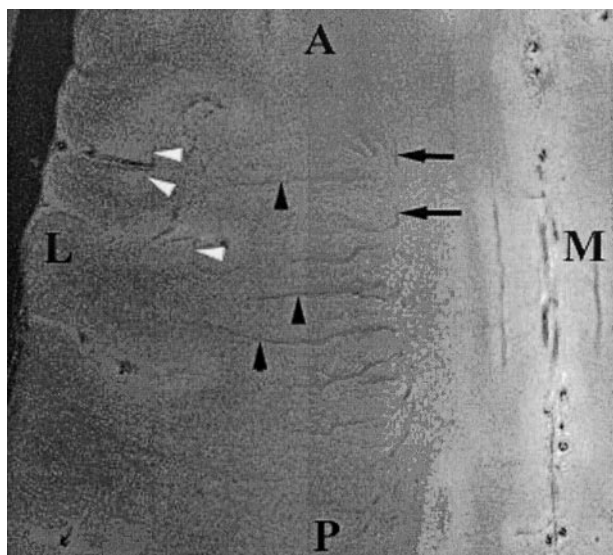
Axial gradient-echo 8-T MR images (600/12, 23° flip angle, 2-mm section thickness, 1024 × 1024 matrix, 20-cm FOV) display the medullary veins in the head of a healthy volunteer. The image is centered at the centrum semiovale and shows many transmedullary veins (black arrowheads) that drain into the subependymal veins (arrows), which are depicted as linear signal intensity voids converging on the surface of the lateral ventricles. Also note the cortical penetrating veins (white arrowheads). A indicates anterior; L, lateral; M, medial; and P, posterior.
